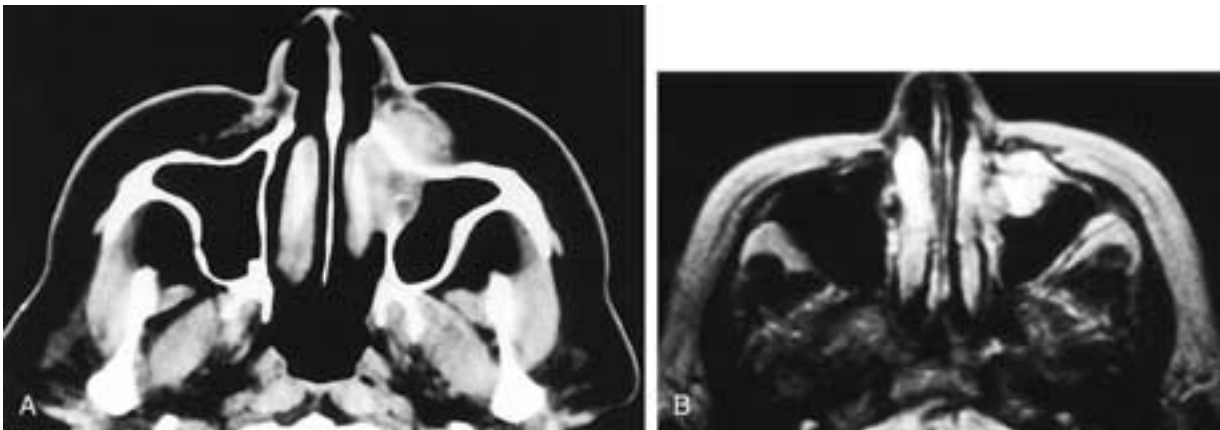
Axial CT scan (A) shows a mass in the anteromedial left maxillary sinus and the adjacent left cheek. There is some destruction of the medial antral wall. In B, a T2-weighted MR image, the mass has high signal intensity. This patient had an adenoidcystic carcinoma.
